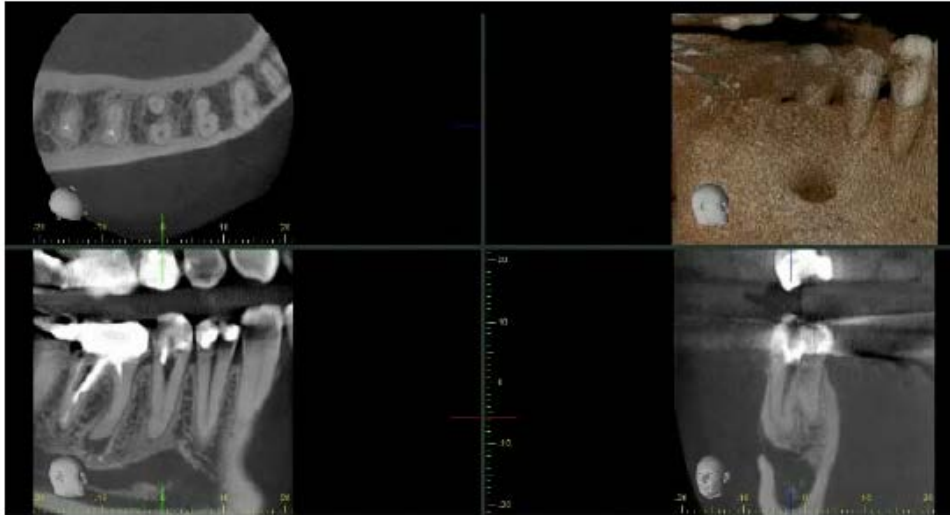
The CBCT imaging reveals the existence of a second root canal in a lingually adjacent root running separately from the main root, along with an apical lucency in the same lingually-adjacent root, and an interradicular lucency in the fircation region.
